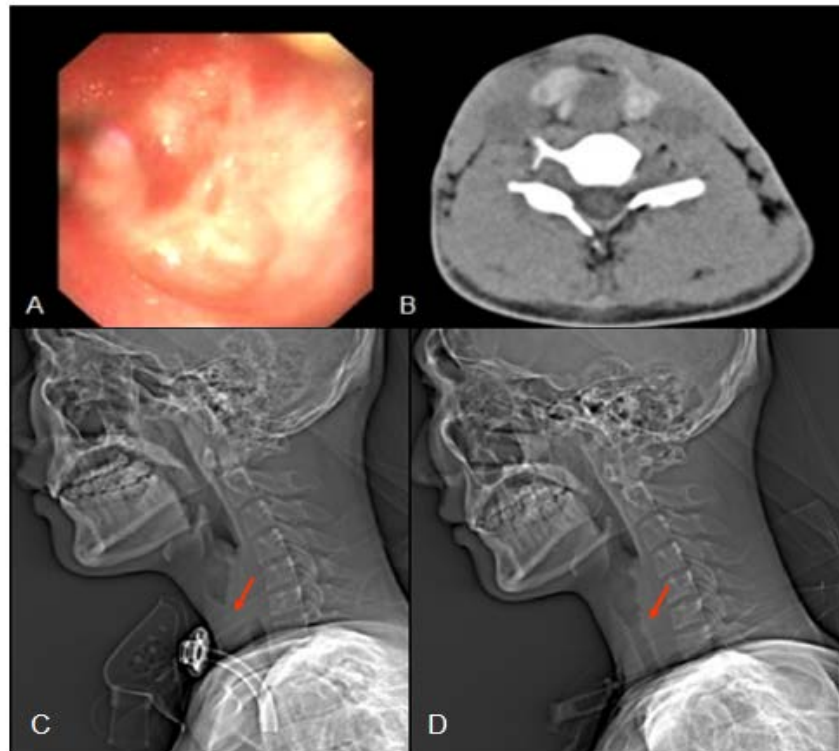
The bronchoscopic result indicated the complete atresia of upper trachea (A). The CT result suggested the complete atresia of cervical trachea (B). Complete atresia of cervical trachea and indwelling metal tracheostomy cannula were found before the operation (C). Airway atresia recanalization was achieved and the indwelling T-tube was observed after the operation (D).
